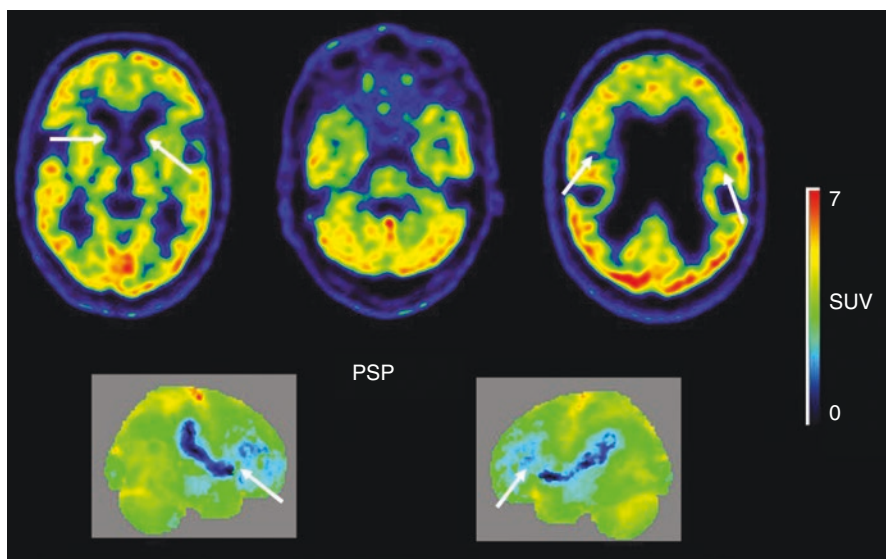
FDG-PET images from a representative case of PSP. Decreased metabolism can be found in the medial frontal cortex and the caudate bilaterally (arrows). Courtesy of Dr. Irina Savitcheva, Department of Nuclear Medicine, Karolinska Huddinge University Hospital
